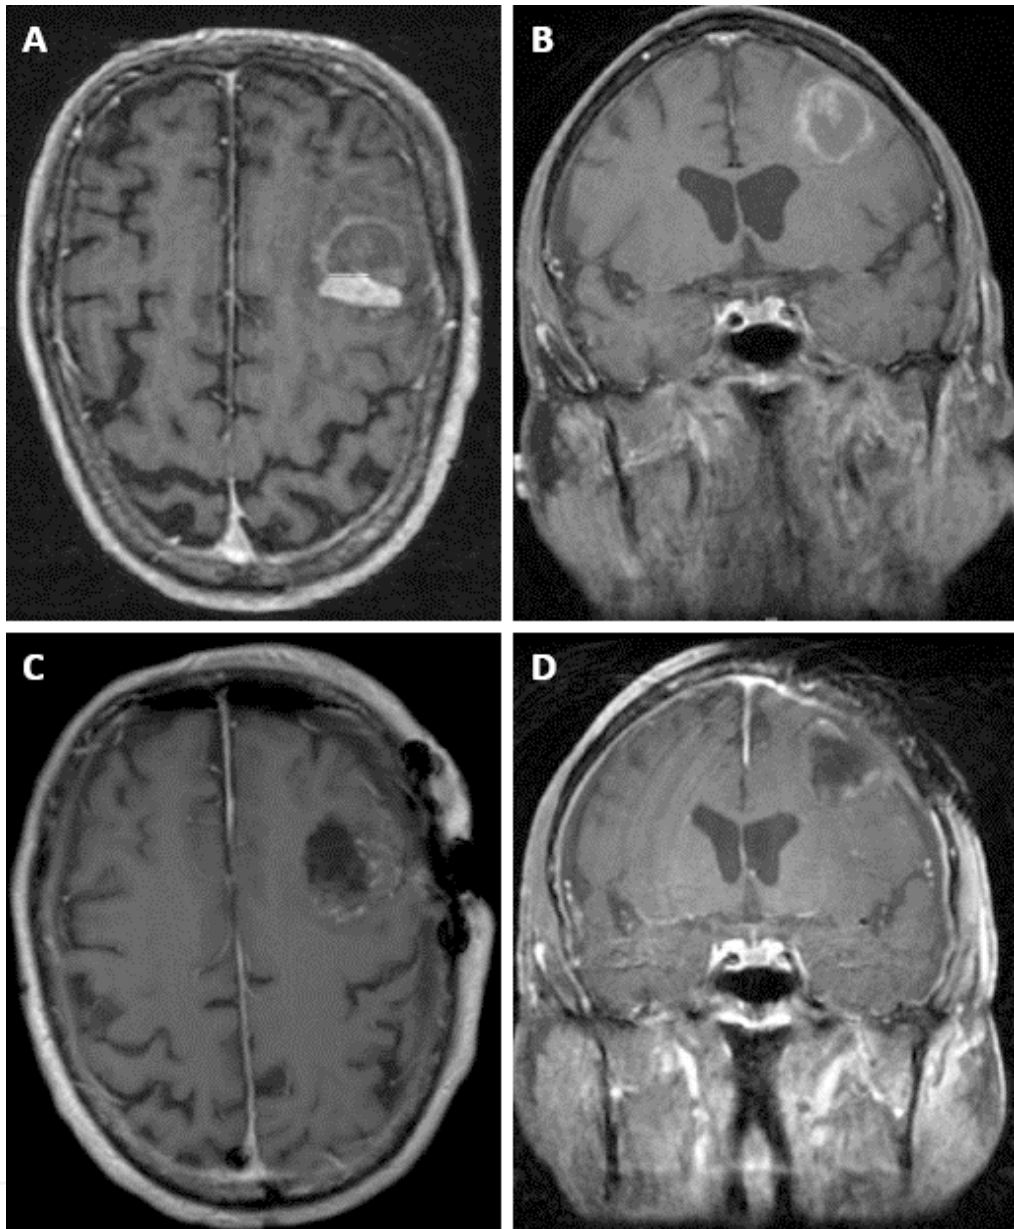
Representative patient with intracranial metastatic melanoma who underwent surgical resection. A, pre-operative contrast-enhanced axial and B, coronal T1 magnetic resonance image (MRI) demonstrating left frontal metastasis with intratumoral hemorrhage. C, post-operative contrast-enhanced axial and D, coronal T1 MRI demonstrating gross total resection of the metastasis.
